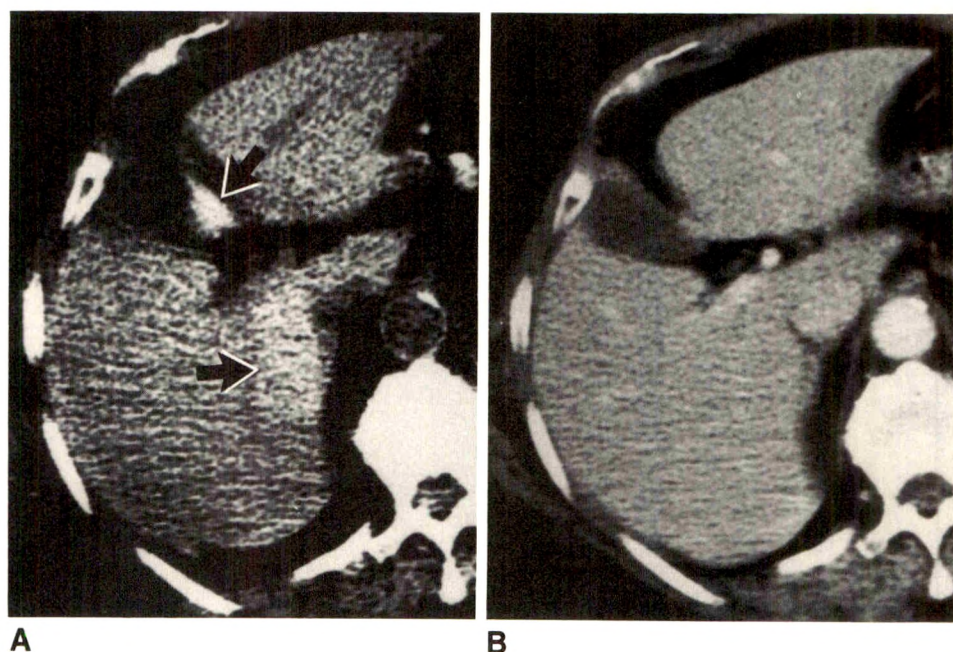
Splenic hematoma in patient scanned with dynamic CT.
